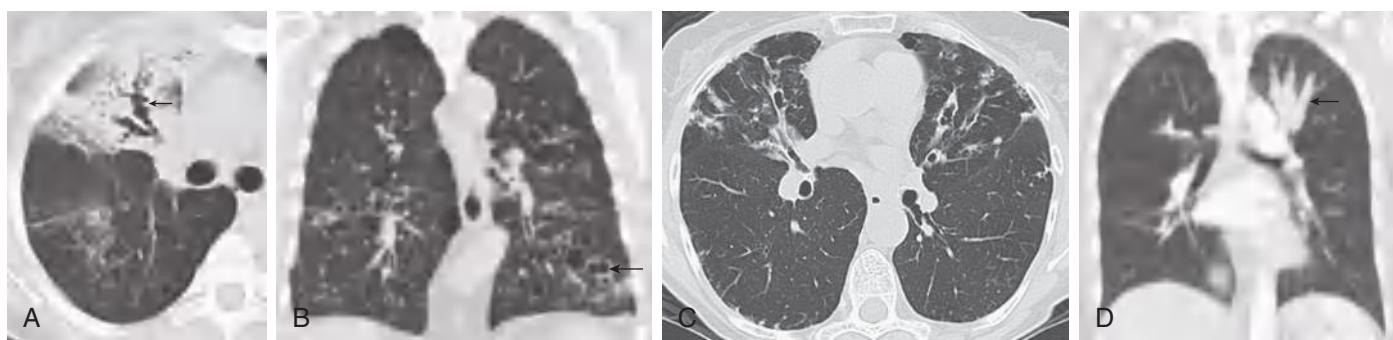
Bronchiectasis. A, Axial CT image demonstrates a beaded appearance of dilated bronchi (arrow) in the right upper lobe, consistent with varicoid bronchiectasis. B, Coronal reformation CT image shows multiple foci of cystic bronchiectasis, with a few air-fluid levels (arrow). Also note paraseptal emphysema, most marked at the right apex. C, Bronchiectatic form of chronic atypical mycobacterial infection. Axial CT scan shows extensive bronchiectasis, bronchial wall thickening, and centrilobular nodules, most severe in the middle lobe and lingula. D, Allergic bronchopulmonary aspergillosis. Coronal reformation CT image demonstrates impacted bronchi in the left upper lobe (arrow) producing a “gloved finger” appearance. (From Boiselle PM. Airway. In: Haaga JR, Boll DT, eds. *CT and MRI of the Whole Body*, 6th ed. Philadelphia: Elsevier; 2017: Figs 40-30, 32-34.)
